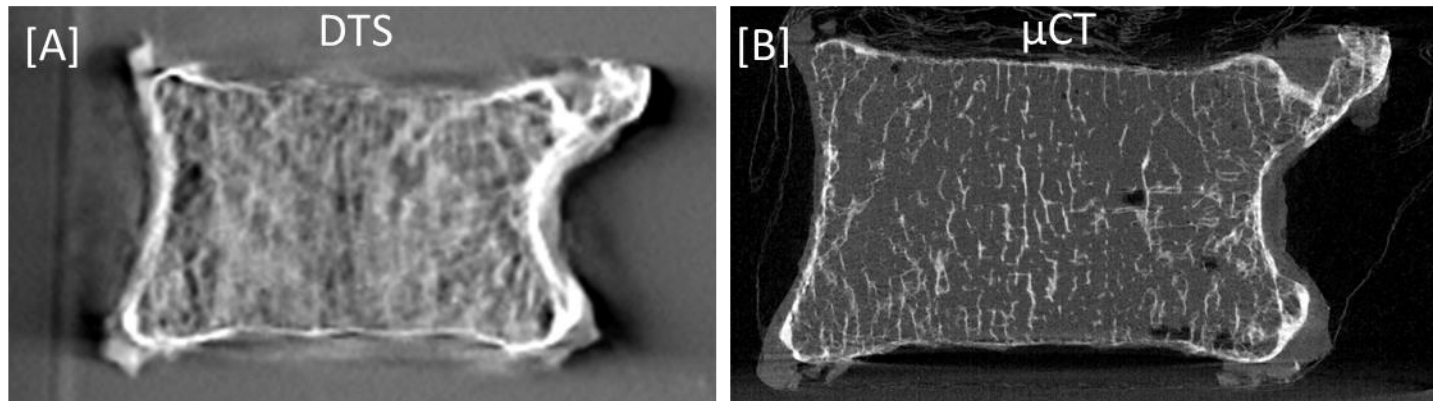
DTS slice (a) and μ CT stack of equivalent thickness (b) were analyzed for MIL, LFD and fractal parameters and then DTS and μ CT generated parameters were compared. DTS image has been inverted for white bone presentation.
